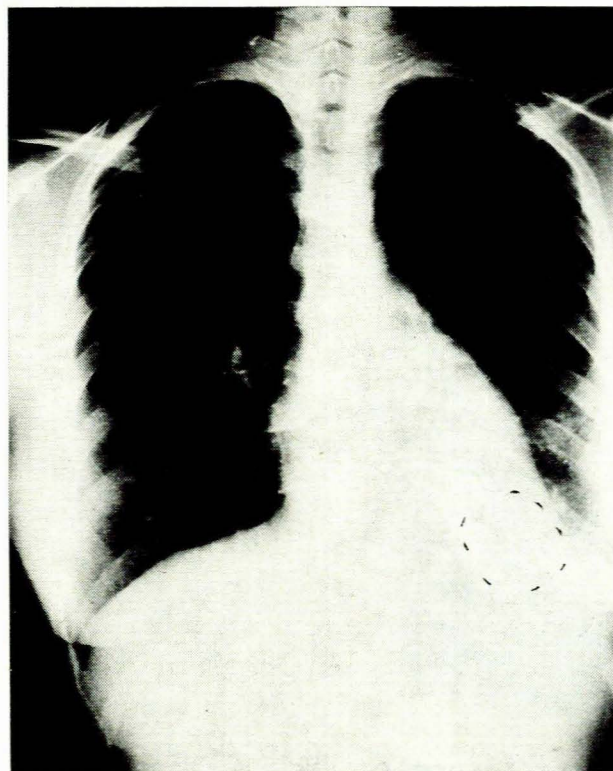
Chest roentgenogram showing the circular density in the inferior left lobe underlying the cardiac shadow.
